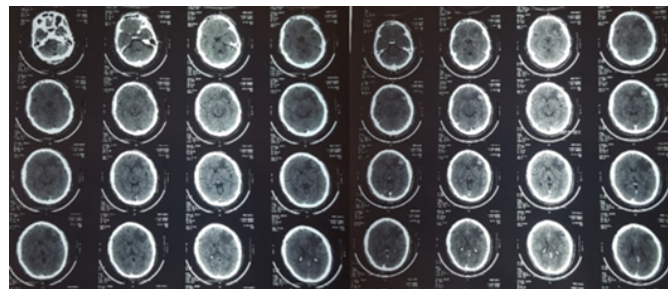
First head CT scan with and without contrast.
